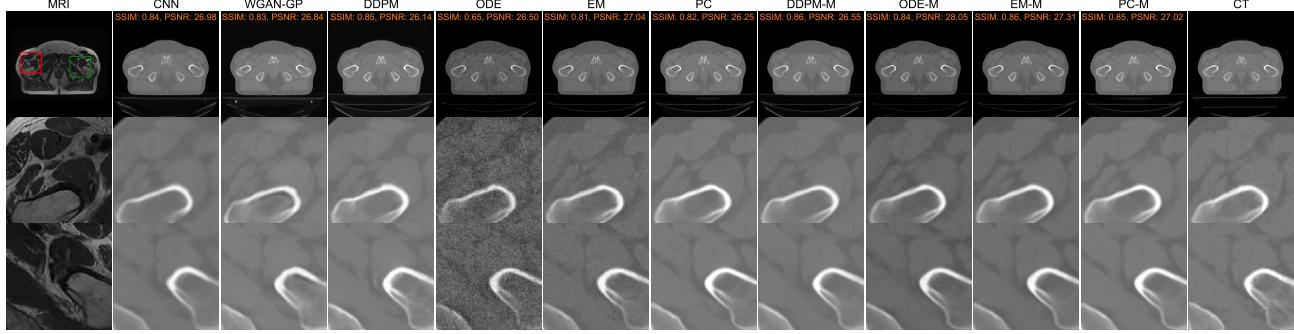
Visual and quantitative comparison of different methods of translating an MR image to a CT image conducted by [32]. The second and third rows indicate zoomed regions in the original image, delineated by red and green boxes. Results after applying the Monte Carlo method (taking an average from ten outputs) using DDPM, ODE, EM, and ODE sampling methods are displayed with DDPM-M, ODE-M, EM-M, and PC-M, respectively.
